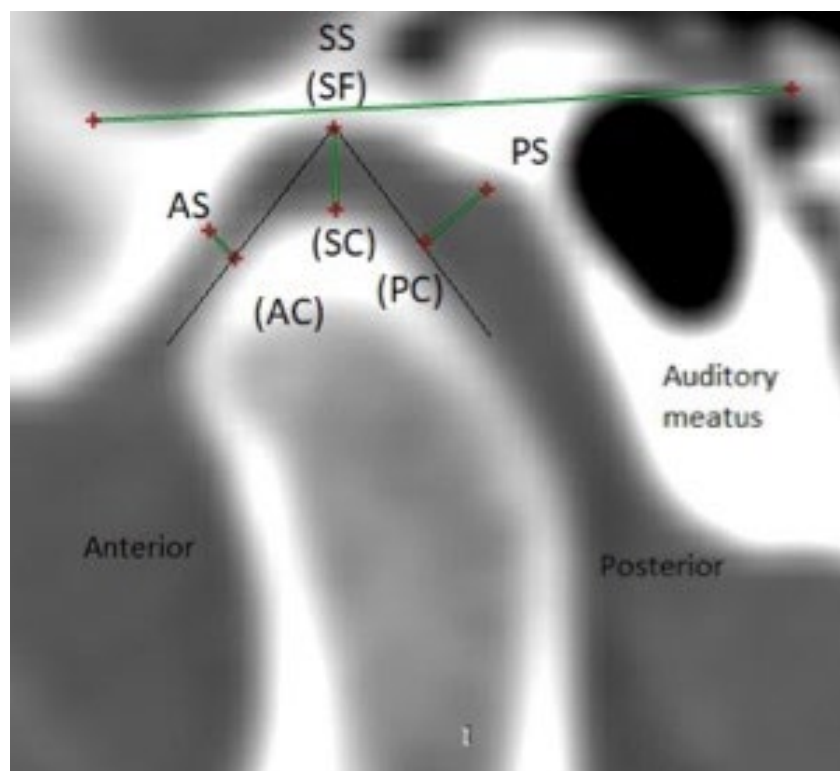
CT image showing landmarks and linear measurements of the TMJ space.
